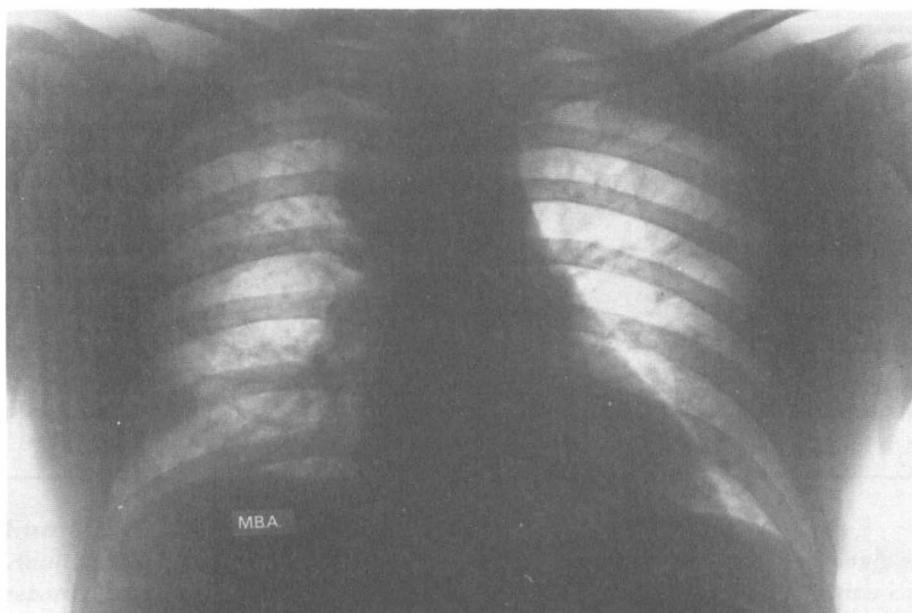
Chest X-ray showing a broad mediastinum and a right paraspinal mass.
